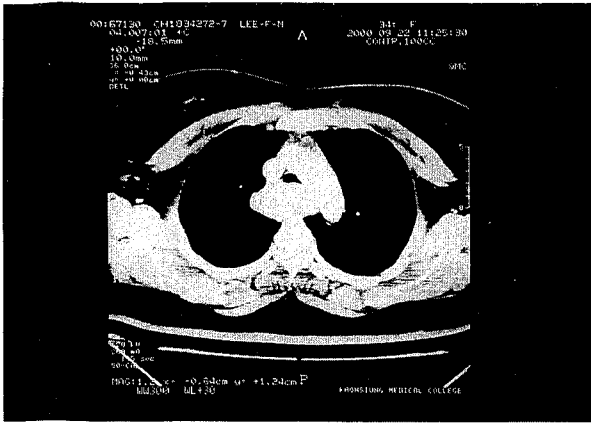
The chest computed tomography showing a $7 \times 4 \times 4$ cm tumor of uniform density on the posterior aspect of the trachea and adjacent to the esophagus.
